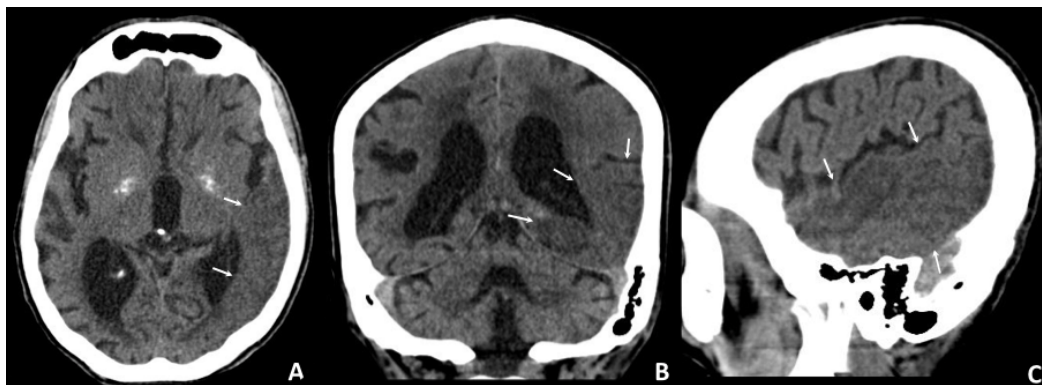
Computed tomography of the brain. (A) Axial, (B) coronal and (C) sagittal images showed ill-defined hypodensities with loss of normal grey-white matter differentiation in the left occipital and temporal lobes (white arrows). This was associated with adjacent ventricular and cerebral sulcal effacement.
